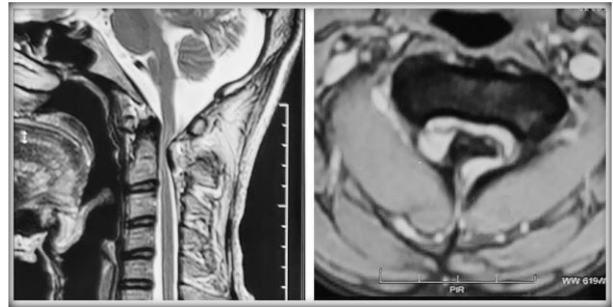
Preoperative magnetic resonance imaging (MRI) of the cervical spine showed a large extradural mass lesion arising from the right C2 vertebral lamina causing major compression at C2 vertebral level with myelopathic changes in the cord.
